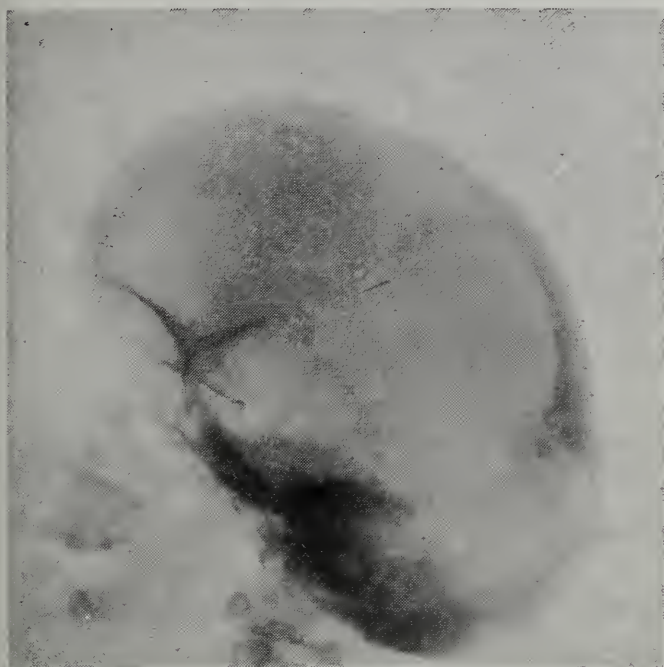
X-ray of the skull shows increased A.P. diameter of the cranium with thickening of the base; evidence of previous Wormian bones in the parieto-occipital areas with prominence of the frontal bosses, which are assymetrical. The paranasal sinuses are poorly developed and there is evidence of defective dentition.
